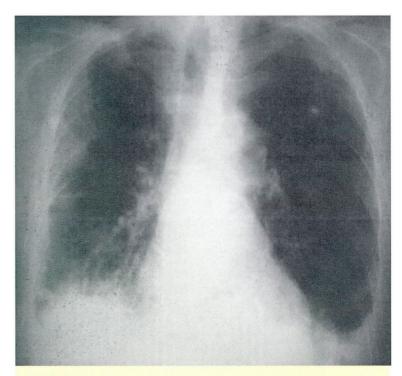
Chest x-ray showing asymmetric interstitial and alveolar changes with a right basal predominance consistent with amiodarone toxicity.
